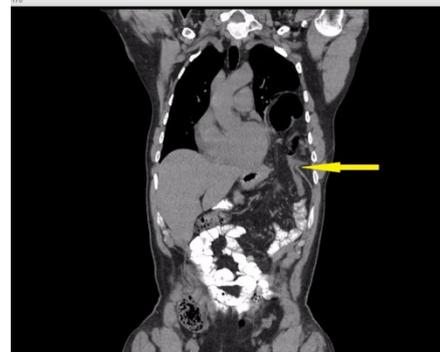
Omental and colonic herniation in coronal computed tomography scan, yellow arrow shows the diaphragmatic defect.
